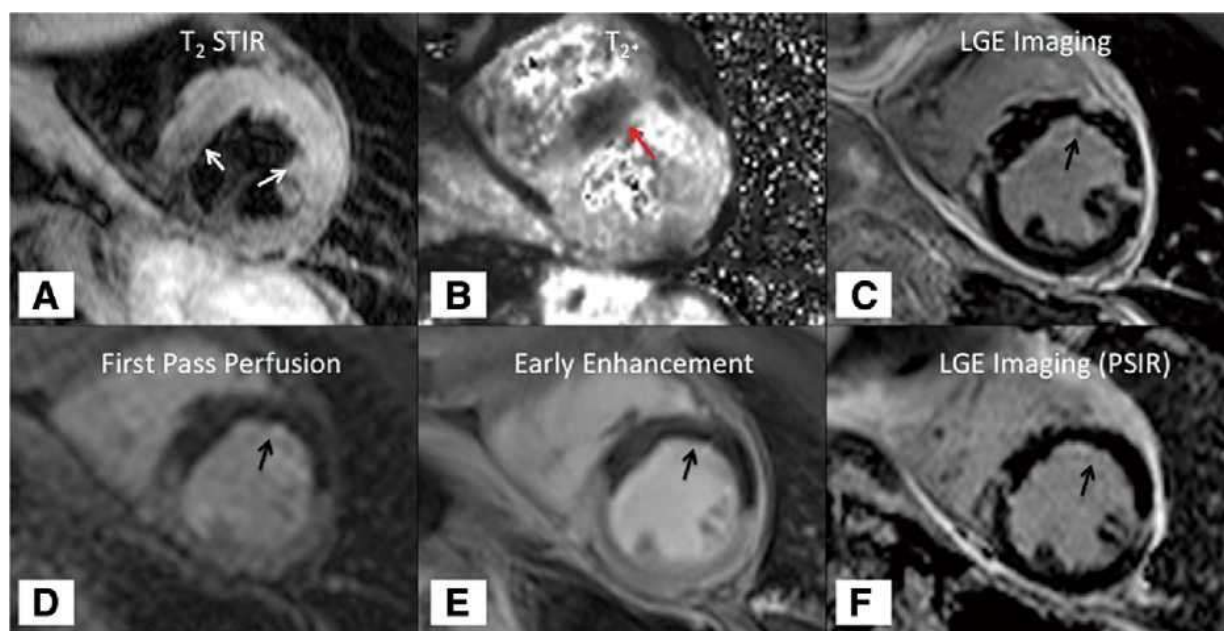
Different aspects of reperfusion injury explored by contrast-enhanced cardiac magnetic resonance imaging (MRI) in an acute anterior STEMI patient.
